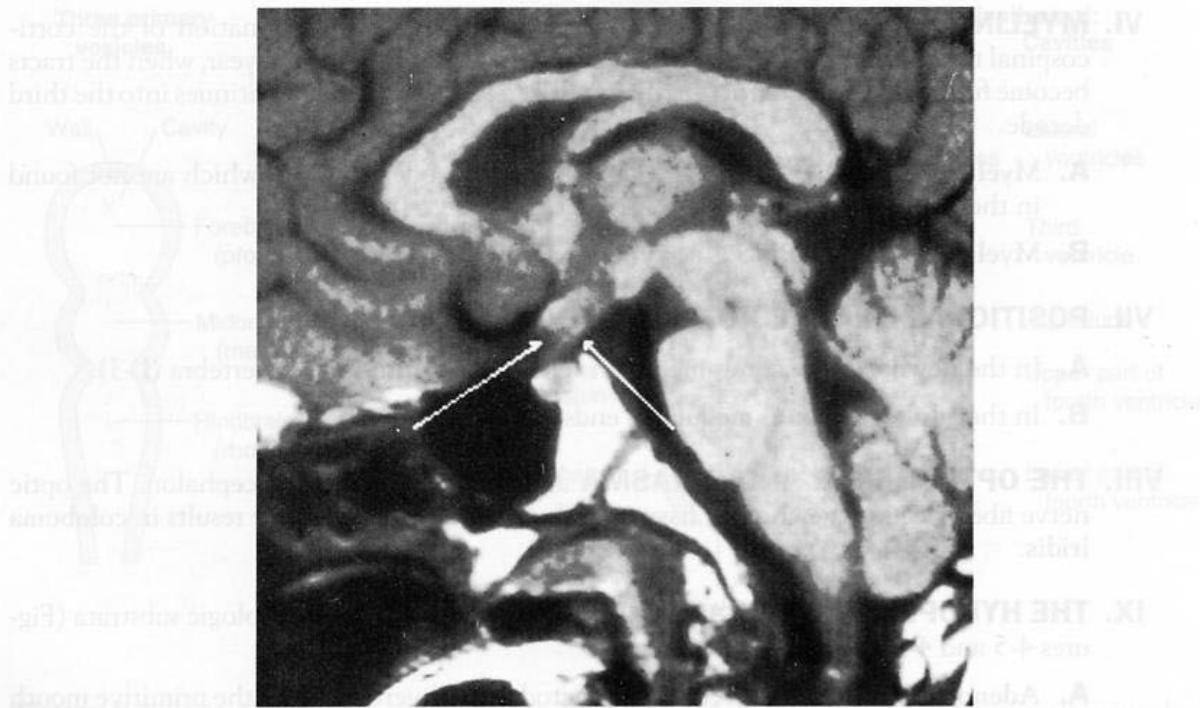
Midsagittal section through the brain stem and diencephalon. A craniopharyngioma (arrows) lies suprasellar in the midline. It compresses the optic chiasm and hypothalamus. This tumor is the most common supratentorial tumor that occurs in childhood and the most common cause of hypopituitarism in children. This is a T1-weighted magnetic resonance imaging scan.
